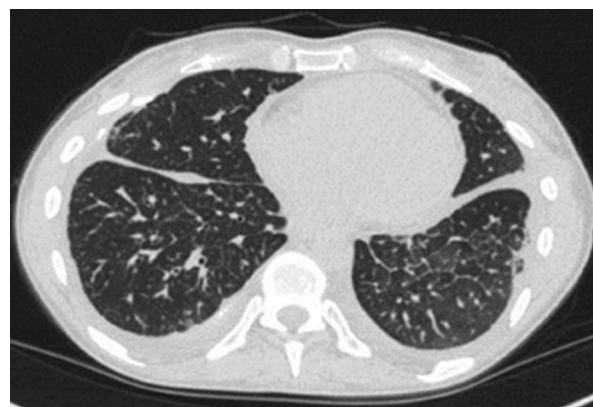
CT scan showing bilateral interlobular septal thickening.
